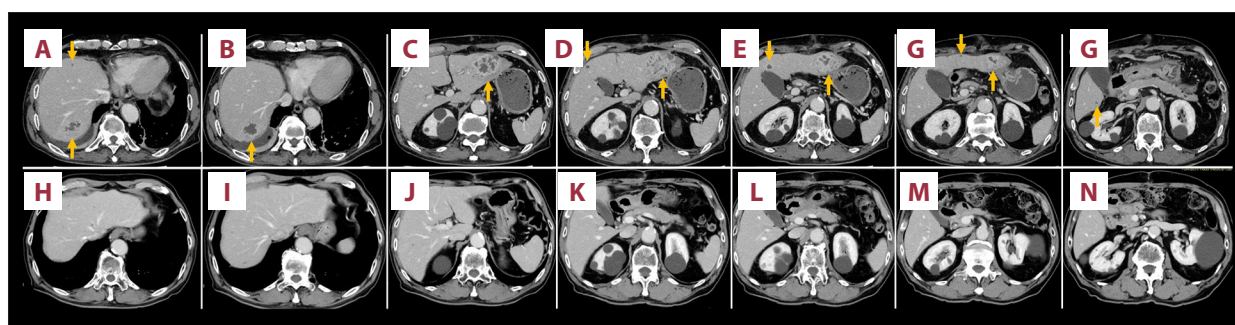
Changes in multiple pyogenic liver abscesses. CT revealed that the multiple liver abscesses (orange arrows) had increased in both size and number on POD 8 (A-G). These abscesses had disappeared approximately 4 months after confirmation of complete removal of the scad bone (H-N). CT, computed tomography; POD, postoperative day.
